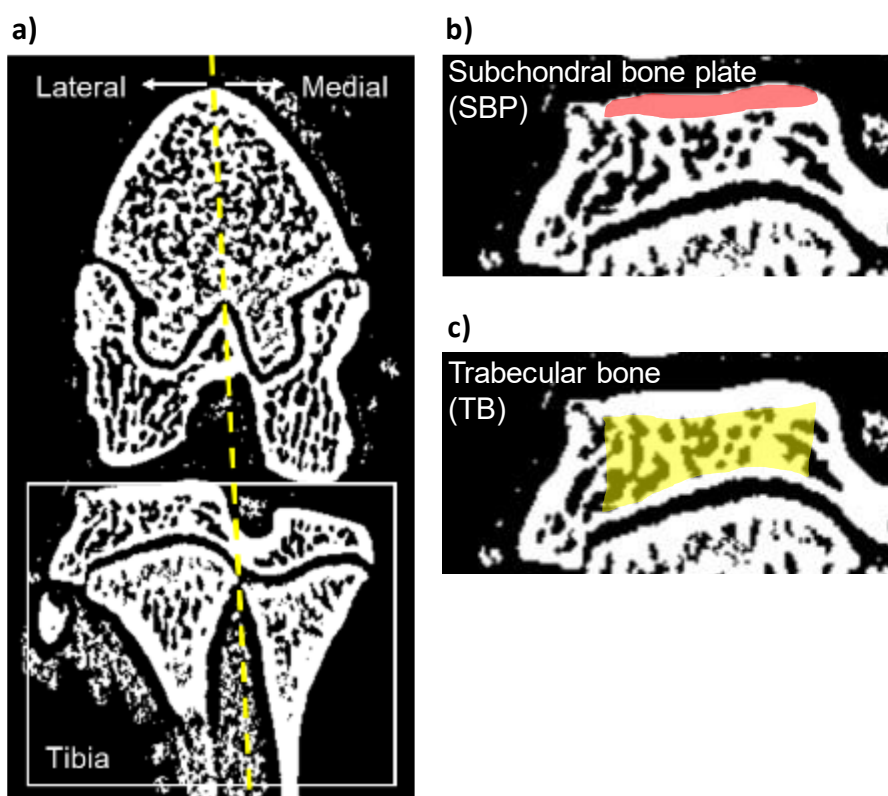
a) Knee joint structure represented by means of 2D micro-computed tomography (μ CT), and respective example of the regions of interest (ROI) selected for μ CT analysis: b) Subchondral bone plate (SBP) denoted by the selected region (red); c) Trabecular bone (TB) - depicted by the selected region (yellow).
